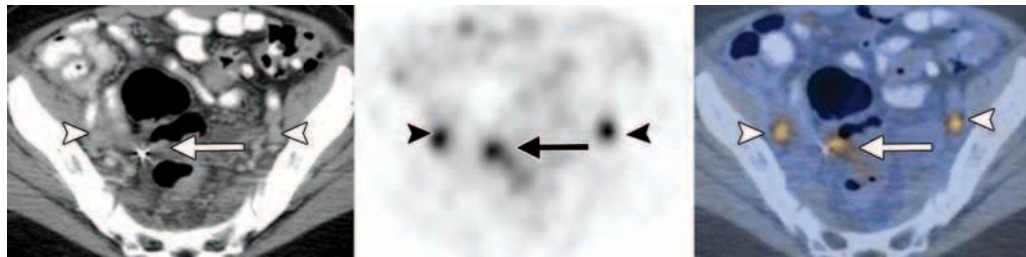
Lymph node metastasis in a 68-year-old woman with elevated CA-125 levels and a history of TAH, BSO, and chemotherapy for stage IIIC ovarian clear cell carcinoma. Axial contrast-enhanced CT (left), FDG PET (middle), and fused PET/CT (right) images show subcentimeter enhancing bilateral external iliac lymph nodes (arrowheads) that demonstrate increased metabolic activity, a finding indicative of lymph node involvement. An additional focus of hypermetabolic activity (arrow) is seen adjacent to a surgical clip, a finding suggestive of local recurrence. Note that the CT image does not show a definitive mass lesion next to the surgical clip, a finding probably due to the small size of the mass and the presence of metallic artifacts. Results of subsequent pelvic washing were positive for malignant cells. PET/CT may help detect residual or recurrent disease in the posttherapy setting when CT results are inconclusive due to anatomic distortion or the presence of metallic artifacts.
